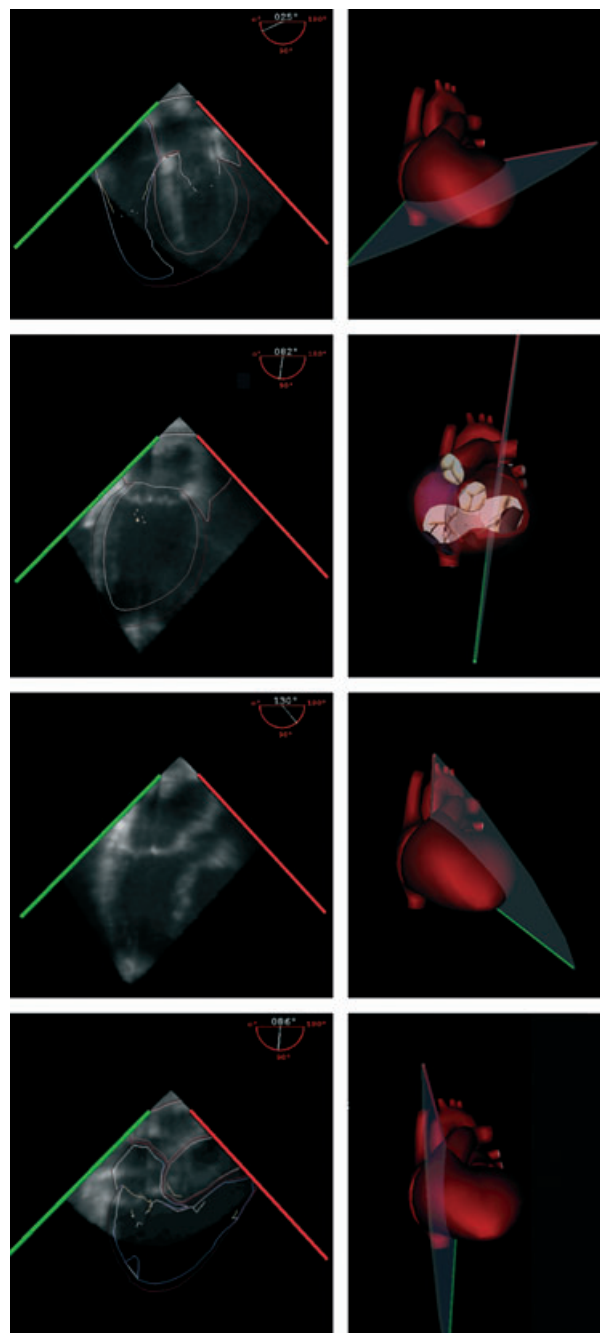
Rotation of the image plane from 25° to 130° (first three pictures). The virtual heart is oriented in an antero-posterior projection. In the second picture the chambers are visualised transparent. In the third picture the contours of the virtual heart are not visualised in the echocardiographic image. The lower right picture shows a rotation of the probe to the right to visualise the right side (right ventricular inflow-outflow view). Since the RV free wall is not included in the echocardiographic data set, only the contours of the heart model are visualised.
